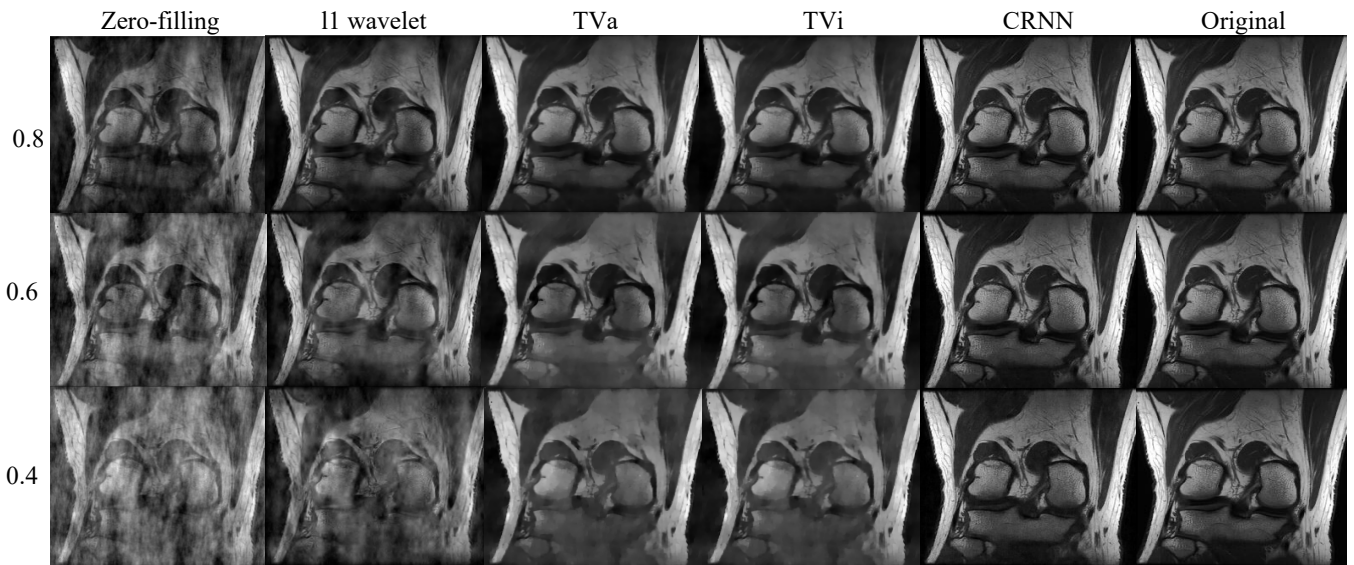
Reconstructed knee MR images based on different methods.
